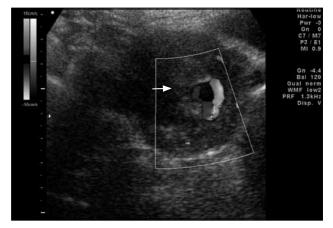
Pseudoaneurysm at the left uterine artery. Homogenous shadow with 'yin-yang' sign<sup>5</sup> on colour Doppler ultrasound is shown (arrow)
